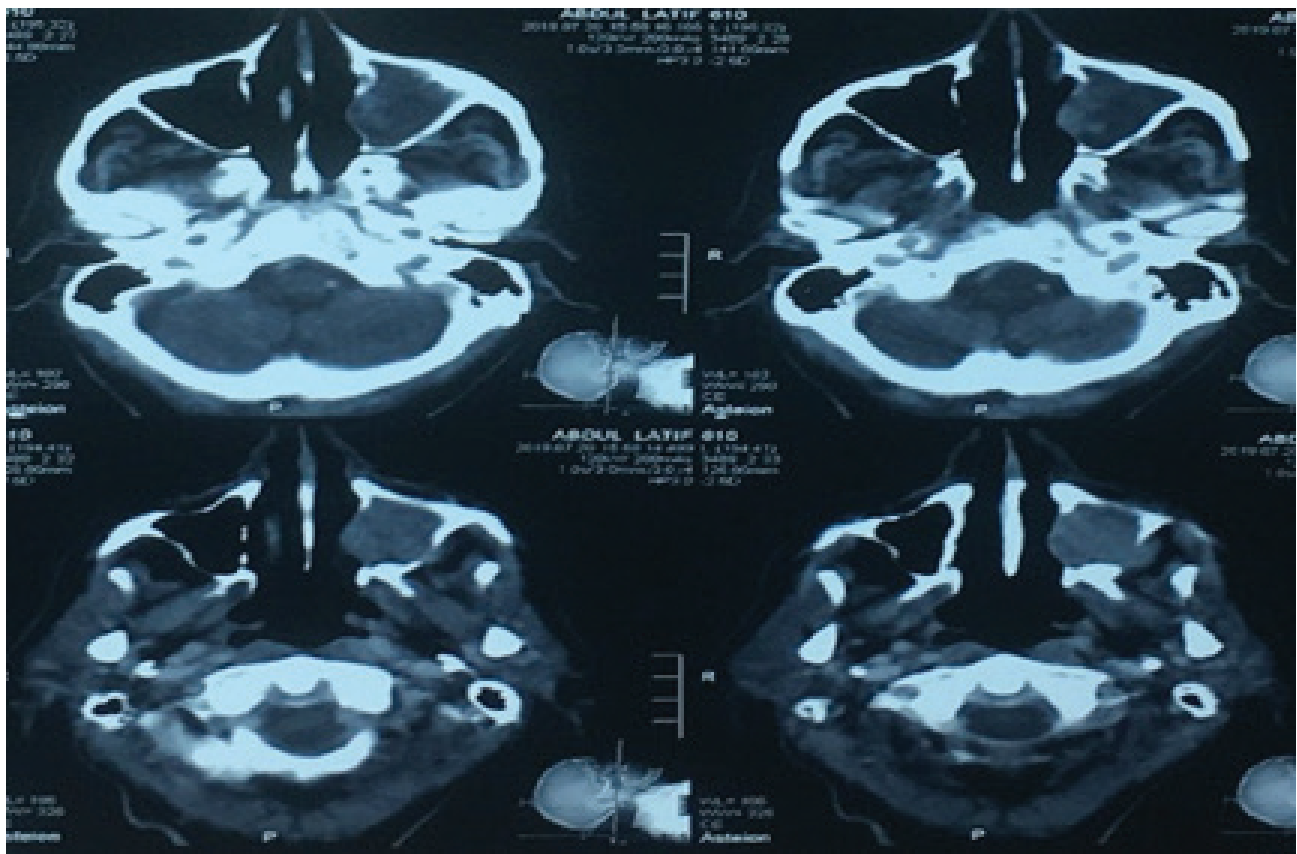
CT manifestation of tumor showing well-lobulated heterogeneously enhancing soft tissue density mass infiltrating left maxillary antrum with the destruction of inferior, anterior, medial, and lateral maxillary wall with the involvement of left-sided hard palate as well as maxillary alveolus.
